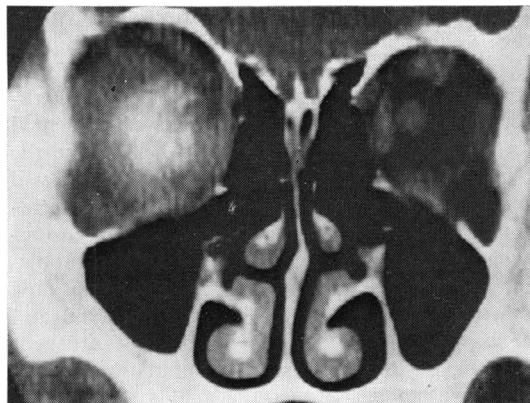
Coronal CT scan showing a large optic nerve meningioma with central calcification.
